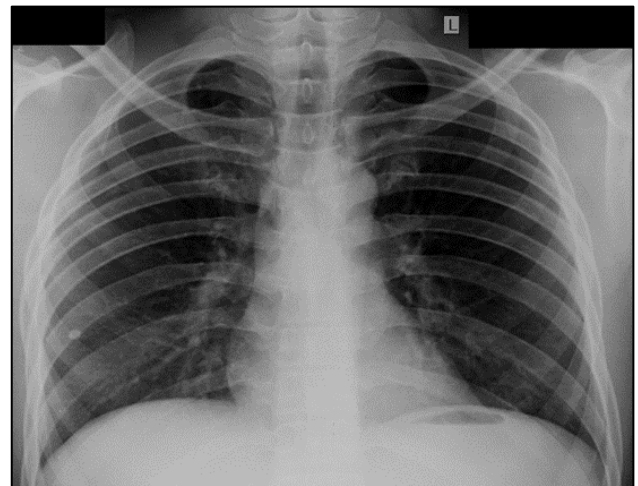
PA X-ray of the chest showing a clear chest.
